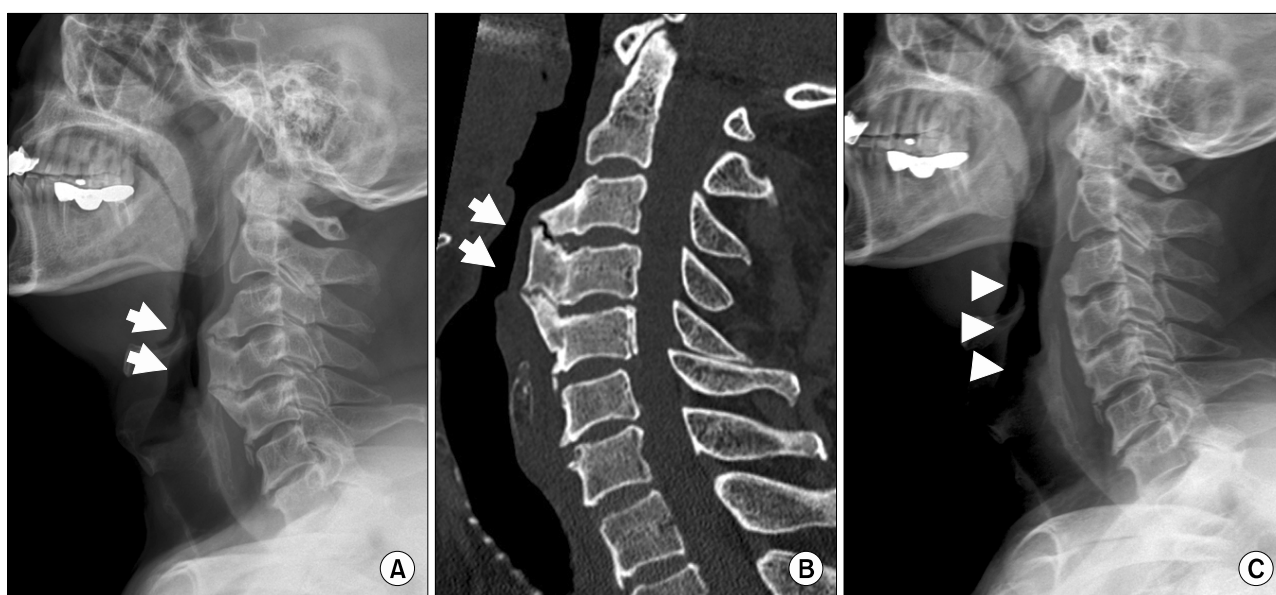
(A) It shows ossification of the anterior longitudinal ligament (OALL) from C3 to C5 (arrows). (B) Cervical computed tomography image shows compression of trachea by OALL (arrows). (C) Postoperative cervical radiograph shows removal of OALL which have compressed the esophagus and trachea (arrow heads).
